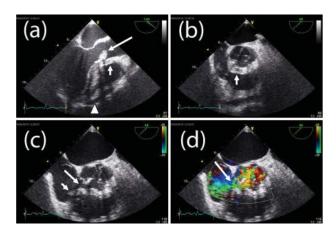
(a). Initial transoesophageal echocardiography demonstrated a 1.3 x 1.0 cm vegetation (long arrow) at the aortic valve as well as aortic root thickening suggesting oedema or possible abscess formation (short arrow). Pericardial effusion (arrow head) was also observed. (b). Repeated transoesophageal echocardiography 1 week later showed the bicuspid aortic valve with an abscess (short arrow) in the short axis aortic valve view. (c). The same TOE performed 1 week later showing the fistula (long arrow) connecting aortic root to right atrium. A vegetation was also observed at the septal leaflet of the triscupid valve (short arrow). (d). Colour doppler applied to the same image as (c) confirmed the flow through the aorto-atrial fistula (short arrow).
